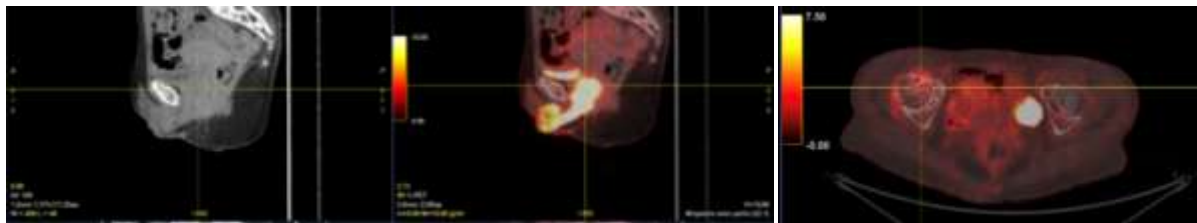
PET-CT findings showing involvement of the vulva following progression to a T4N1M0 lesion (sagittal and axial views).
